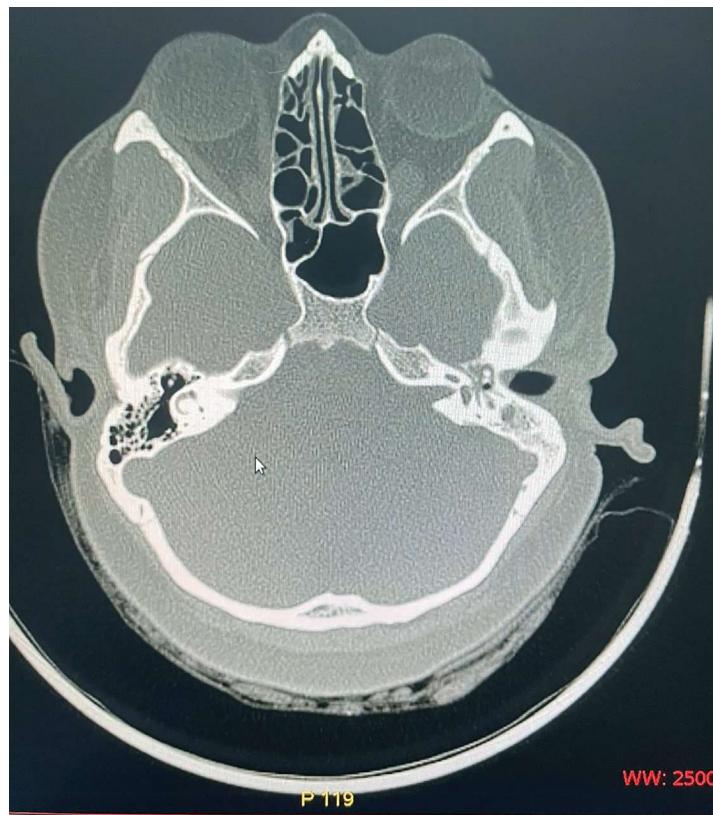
HRCT Temporal Bone axial section of epitympanum from the console showing a small defect of epitympanum, presence of soft tissue density in left epitympanum and mastoid air cells with partial necrosis of body of incus. Medial part of external auditory canal is opacified
